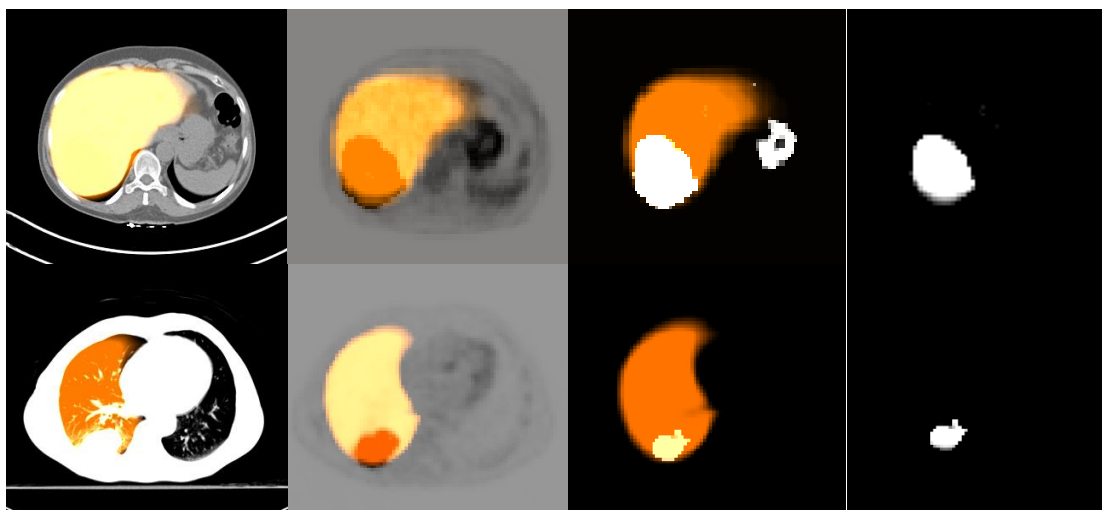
DQ-AAR on liver (top row) and lung (bottom row). Left column is the recognition results (in yellow) of liver and lung on the CT images, and the second column is the recognition results from CT being propagated to PET image. Third column is the recognition results being overlaid onto the disease map of the whole image and last column shows the final disease map.
